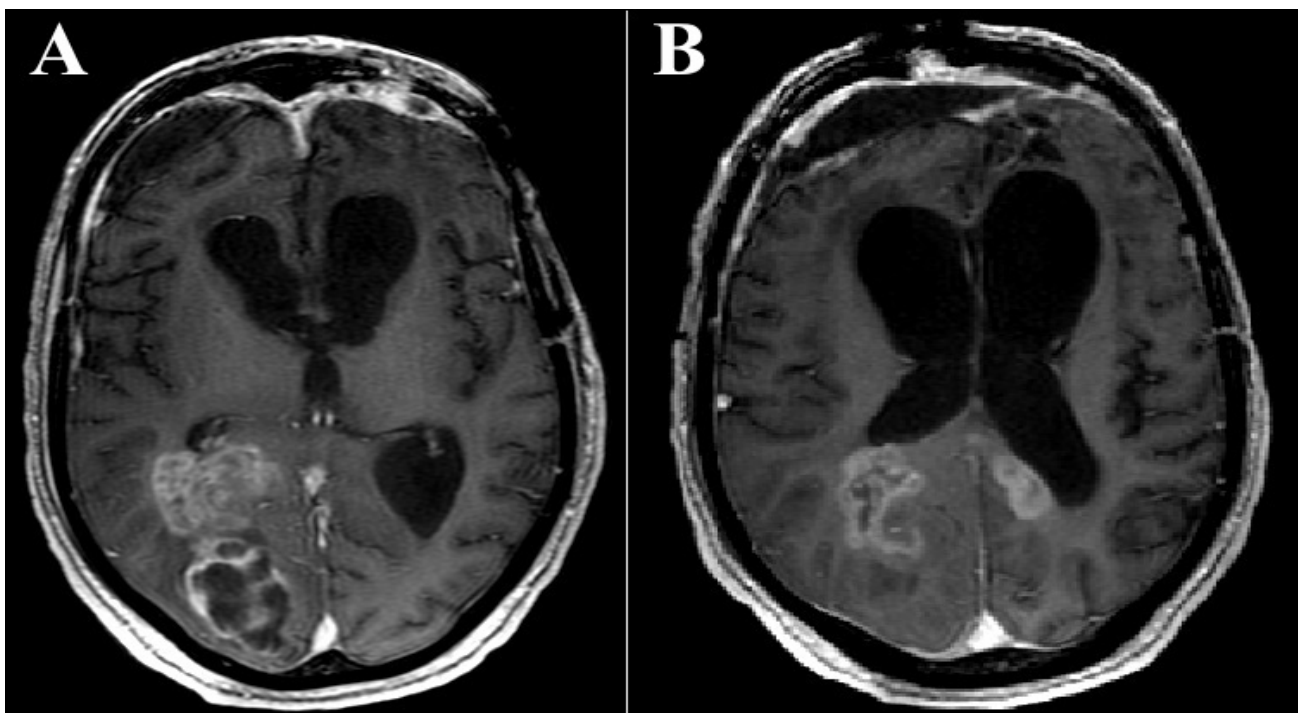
Subsequent MRI revealing a significantly developed Glioblastoma Multiforme in the right parieto-occipital lobe: A) Axial T2 weighted MRI with contrast show mass effect and lateral ventricular compression within the right parieto-occipital lobe; B) Axial T2 weighted MRI with contrast showing contralateral hemisphere involvement- a classic “butterfly” sign- and mass effect
